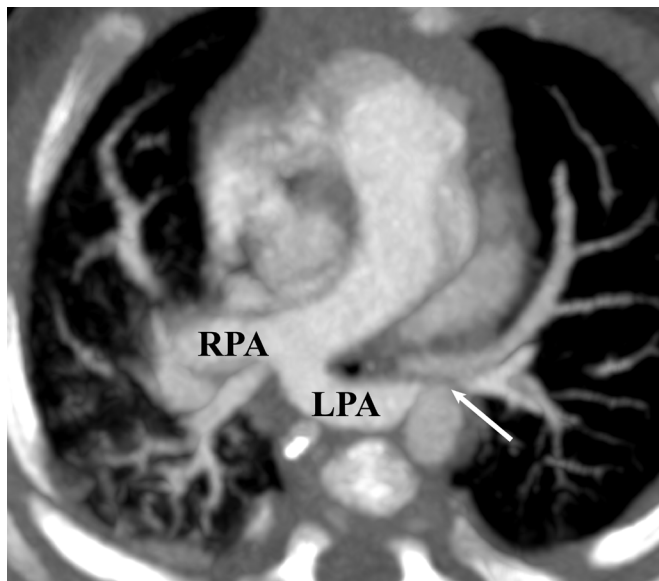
Chest computed tomography showed a typical imaging feature of pulmonary artery sling including pulmonary artery sling with an abnormal origin crossed between the esophagus and the main trachea and a small inner diameter of left pulmonary artery (arrow). (LPA, left pulmonary artery; RPA, right pulmonary artery)
